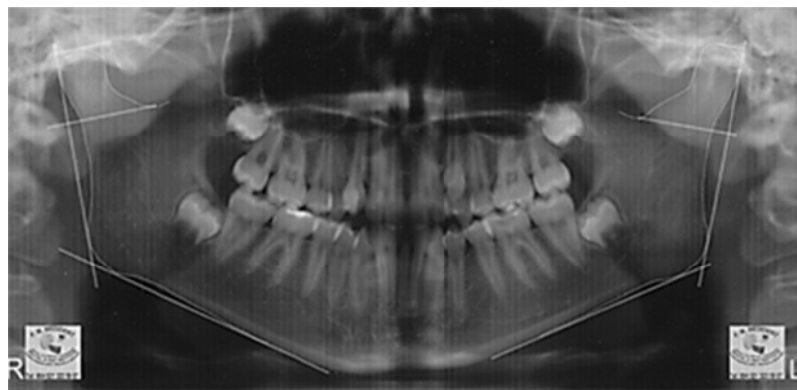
Case A.I., ♀, 14 years old, skeletal Cls. III: orthopantomograph analysis:
